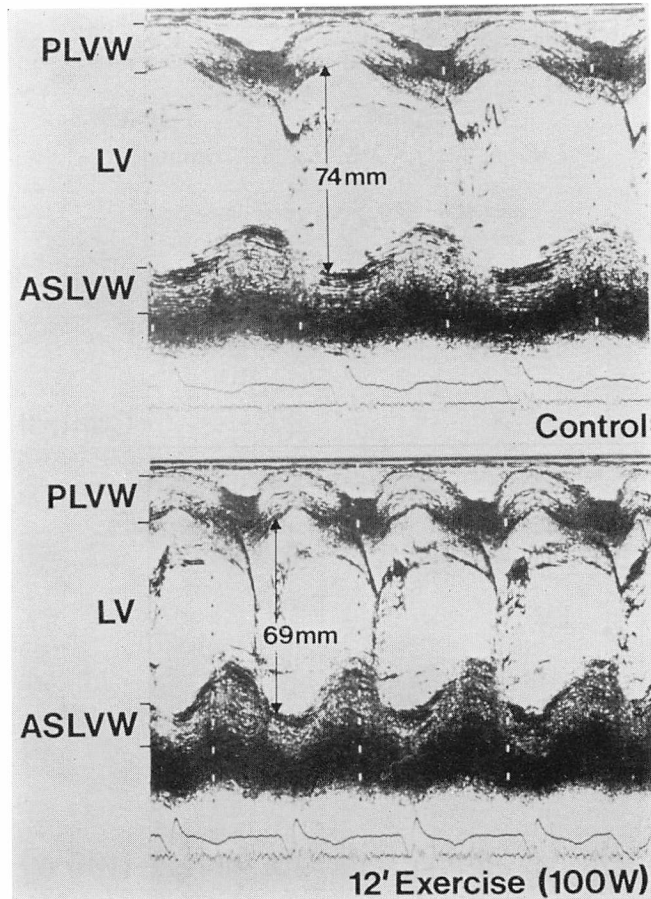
Transesophageal echograms of the left ventricle at rest and maximal exercise in an asymptomatic patient with aortic regurgitation.
